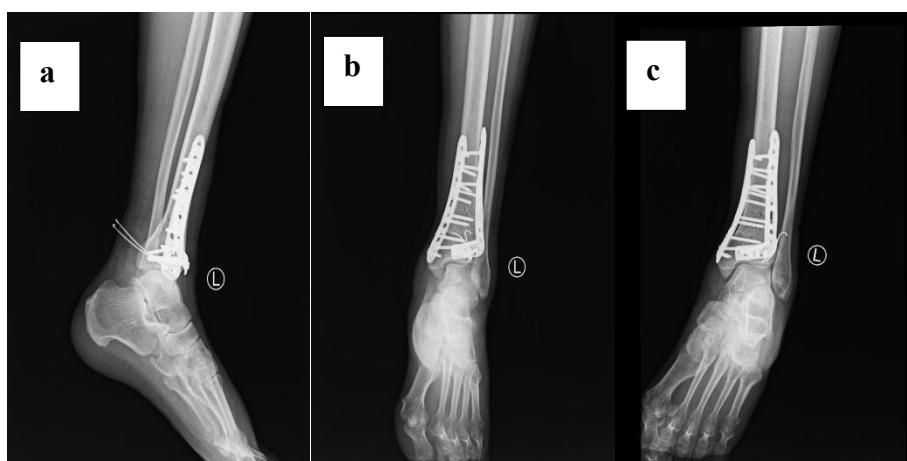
Postoperative X-ray imaging data. a Lateral view; b Anteroposterior view; c Ankle acupoint
